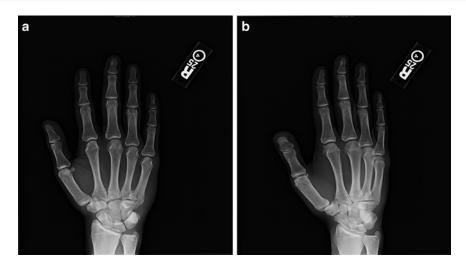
AP (a) and oblique (b) X-rays of small finger metacarpal base fracture
